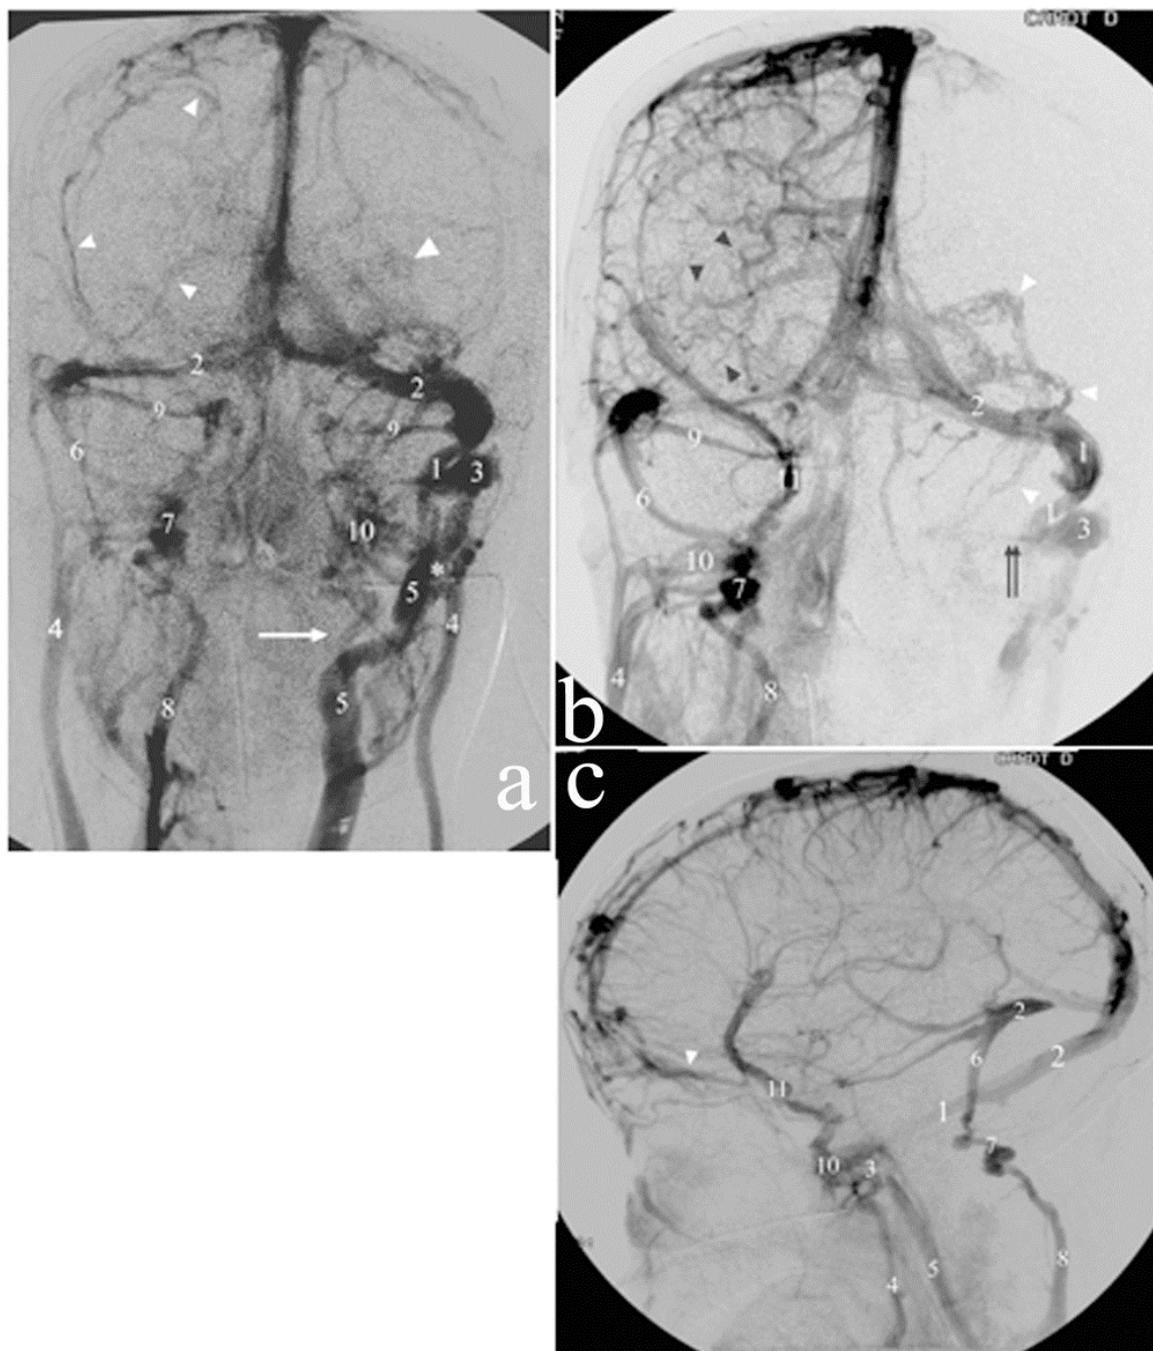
Case 2. DSA (BN3000, Philips, Best, The Netherlands). Aside from confirming the CTA findings, DSA disclosed signs of venous hypertension, partial obstruction of the superior sagittal sinus draining cortical veins from the left convexity (not shown), and compensatory collateral drainage through an enlarged system of diploic veins on both sides 28a. late venous phase obtained after injection of contrast agent into the ascending aorta, anteroposterior view. Same legend as in previous figures. The absence of the left sigmoid sinus is confirmed. The right transverse sinus is hypoplastic compared to the left and drains into a sigmoid sinus (6). Drainage of the right sigmoid sinus occurs through a posterior condylar emissary vein (7) into a deep cervical vein (8). Note the absence of a right IJV. The left pterygoid plexus (10) is prominent and drains into a large deep facial vein, which ultimately becomes a common facial vein (white arrow). Cortical veins have washed out at this stage and only a few prominent diploic veins are recognized (white arrowheads) on both sides, compatible with collateral venous flow. 28b. early venous phase after right ICA injection, anteroposterior view. There is simultaneous opacification of the transverse sinuses.
